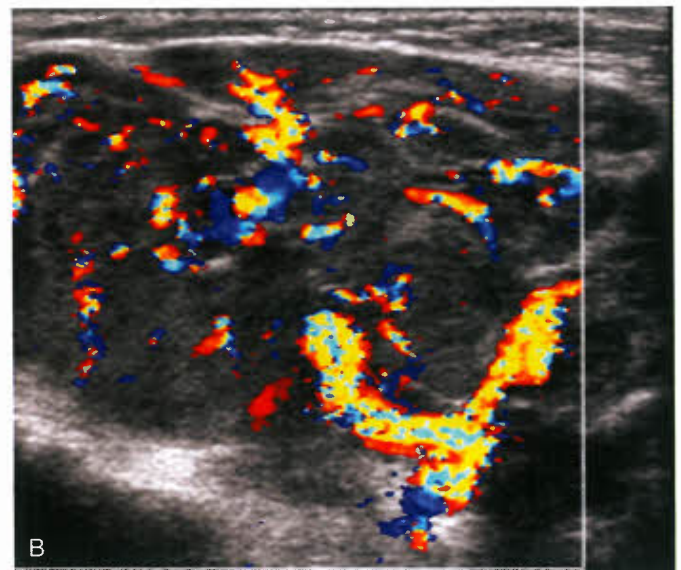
Ultrasonography of infantile hemangiomas. A: Diffuse enlargement of the right parotid gland caused by an infantile hemangioma. B: Marked hypervascularity of the lesion with enlarged feeding arteries.
